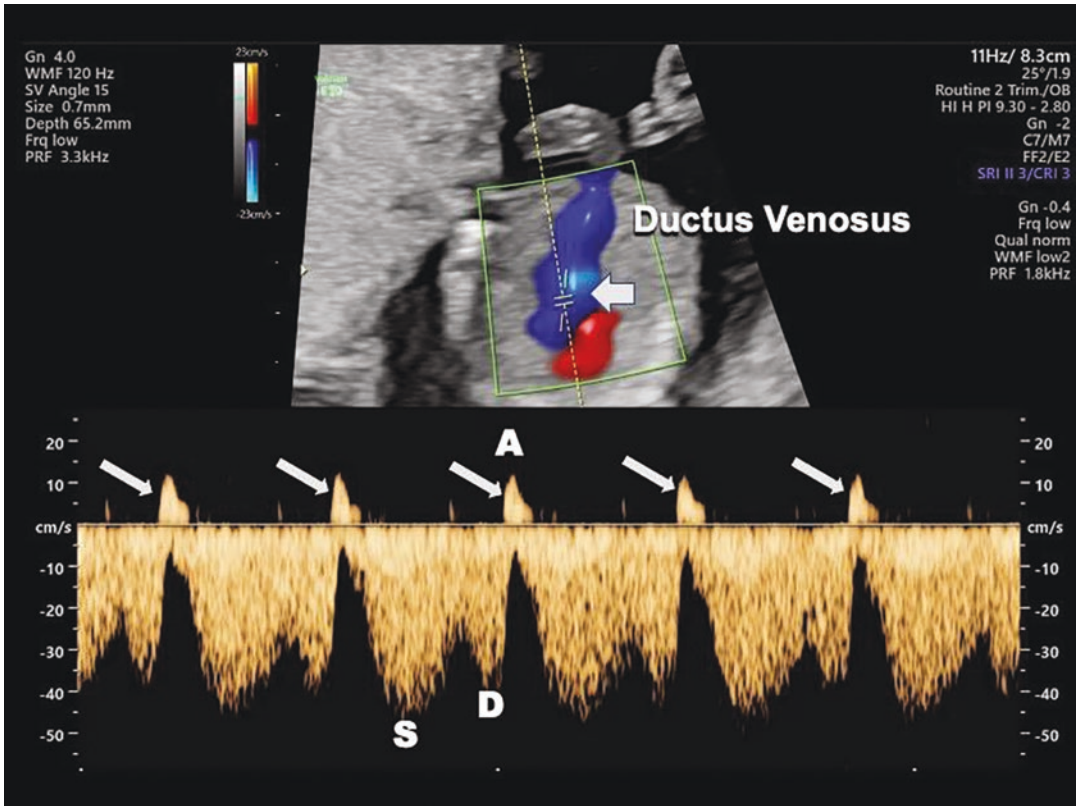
Reversal of flow in the ductus venosus is depicted in color Doppler directed spectral Doppler display. The upper panel, in the oblique axial plane, shows the color Doppler flow in the ductus, and the lower panel
